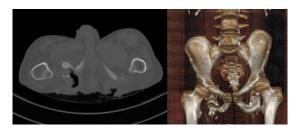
CT pelvis with 3D reconstruction showing features of bilateral chronic osteomyelitis.
